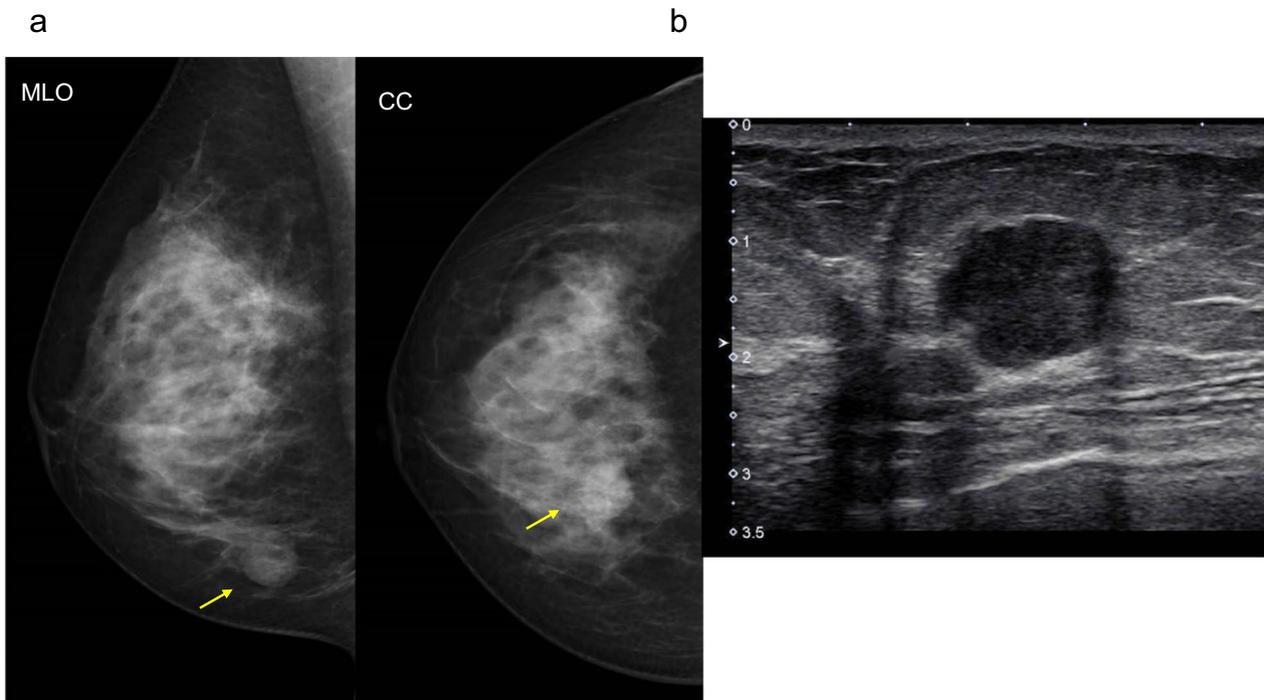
A Mammography (MG) shows a high-density mass with circumscribed margins (arrow). B Intracystic solid component was irregular shape and high vascularity in ultrasonography (US)
